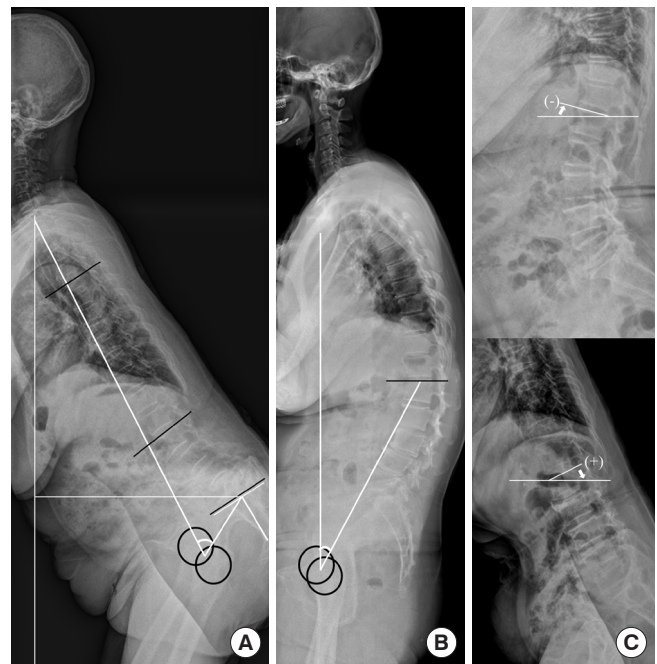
Whole-spine standing radiograph. (A) T1 pelvic angle: angle between the lines from the centroid of T1 to the femoral head axis and from the femoral axis to the middle of the S1 endplate. (B) Thoracolumbar tilt: angle between a vertical reference line and the line connecting the midpoint of the L1 superior endplate to the center axis of the femoral heads. This is a positive value similar to pelvic tilt. (C) Thoracolumbar: angle between a horizontal reference line and the L1 superior endplate. This is a negative value similar to sacral slope.
